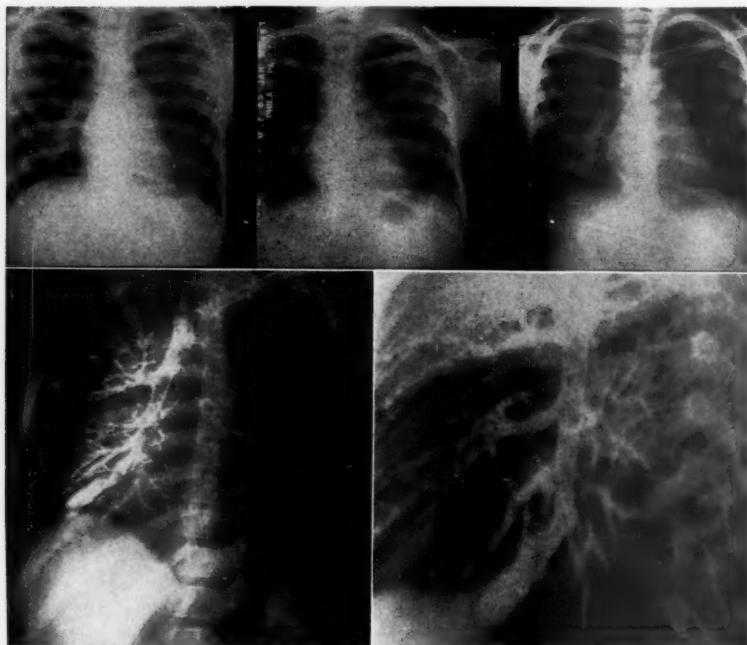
(Above) Case 1 (P.K.) Roentgen films showing abnormal density in the right base of lung overlying the leaves of the diaphragm.
